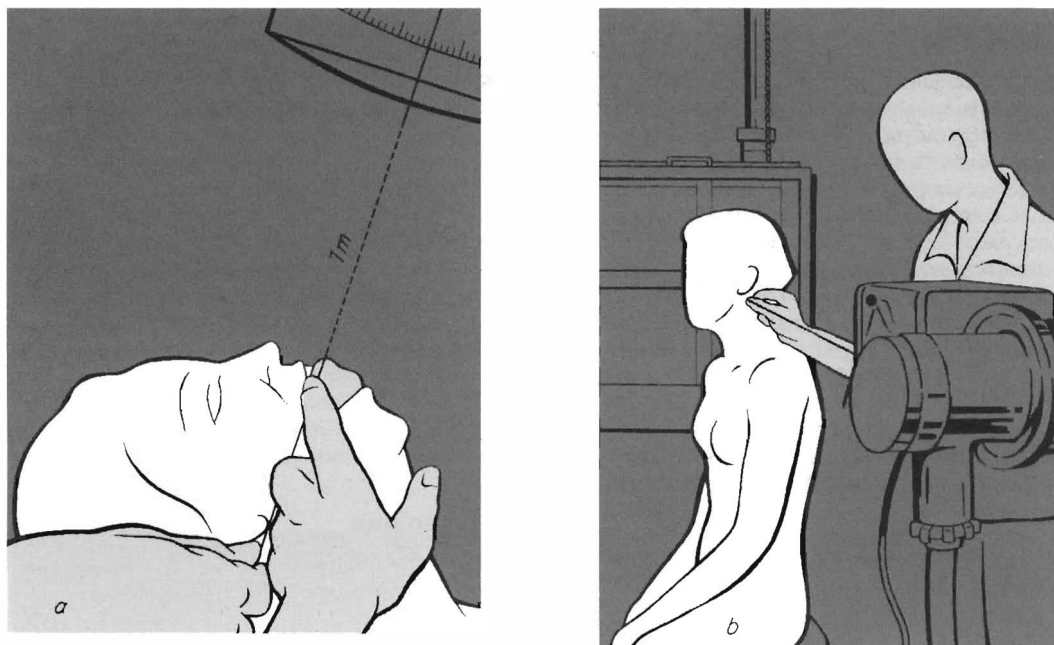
X-ray technique of the cervical spine according to Sandberg (1955). (a) Focusing the central ray in the anteroposterior view with the aid of a string, the head in a horizontal position; (b) focusing the X-ray tube in the lateral view at the mastoid process
